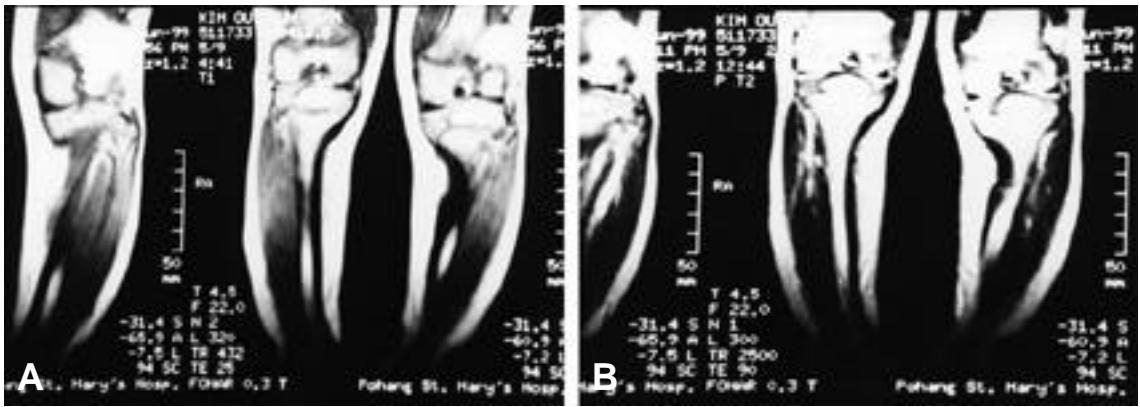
T1 and T2 weighted MR images demonstrate a low signal intensity of the medial cortex of left proximal tibia with cortical thickening.
